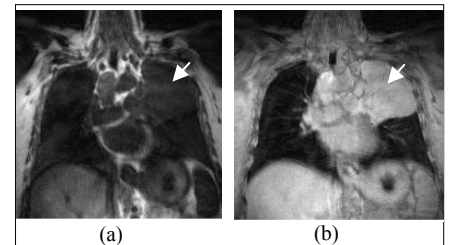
(a) DCE-MRI pre-contrast ($\alpha=25^\circ$) and (b) low flip angle ($\alpha=3^\circ$) images of a lung tumor patient. The tumor is indicated by the arrow.
